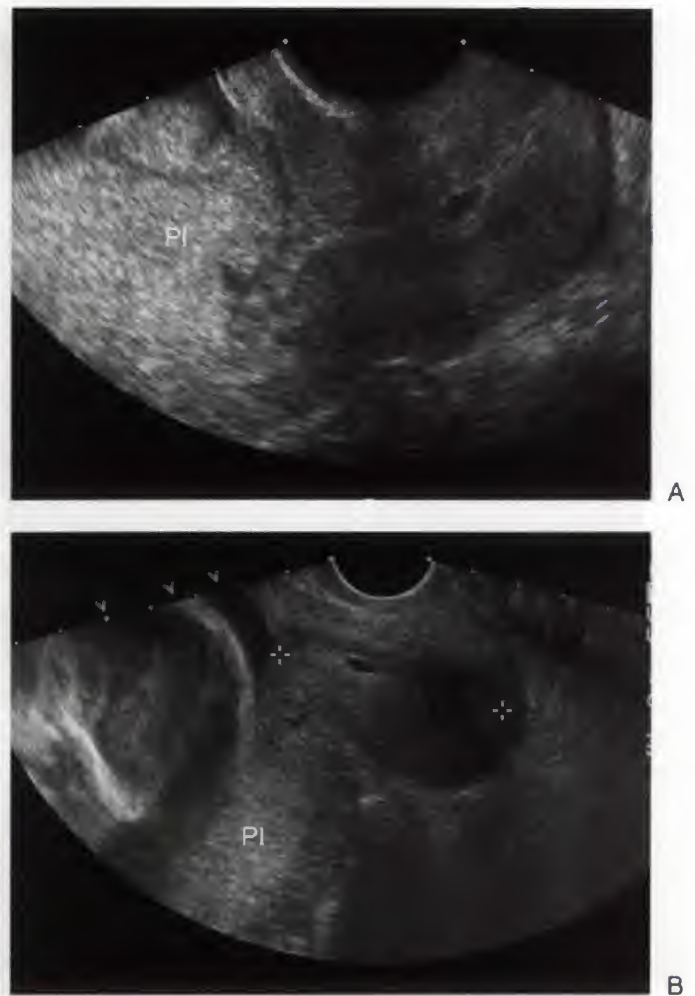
Pseudo placenta previa due to transient myometrial contraction at the lower uterine segment (LUS). *A* and *B*. On initial transabdominal ultrasound views, the anterior placenta (PI) appears to completely cover the internal cervical os, suggesting complete previa. *Asterisks*, lower uterine segment contraction. *C*. Additional TA image obtained 15 minutes later, after focal LUS contraction has resolved, shows the normal appearing cervix (between calipers) without evidence of previa.
